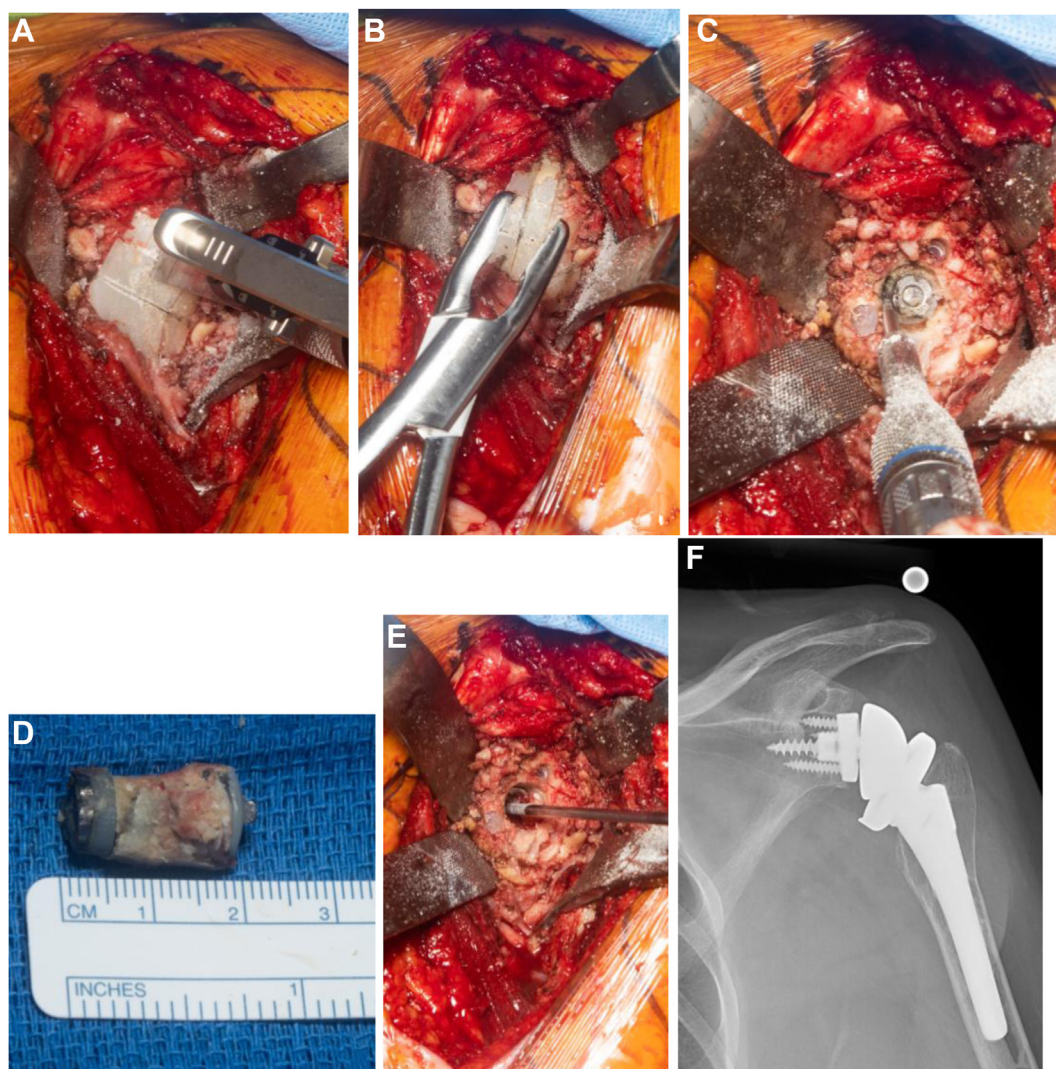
(A and B) demonstrating the technique of splitting the polyethylene with a saw in 2 horizontal and 2 vertical cuts. (C-E) demonstrate the router being utilized to ensure minimal bone resection with complete component removal. (F) is a postoperative radiograph 8 weeks after surgery demonstrating well-placed rTSA components. rTSA, reverse total shoulder arthroplasty.
